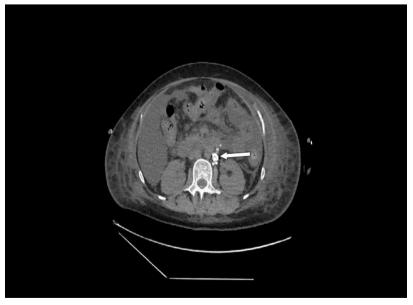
CT in native with contrast agent after lymphography shows the spread of contrast material in lymphatic vessels up to the L1 level.
